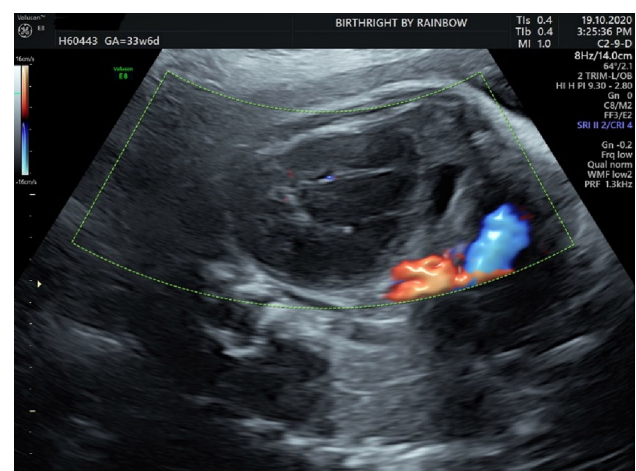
Colour Doppler interrogation
